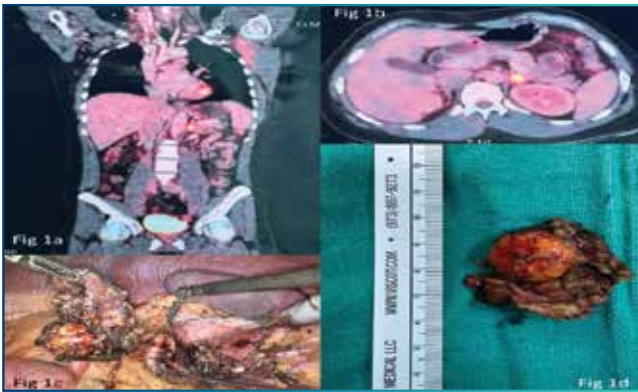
(a) sagittal section, (b) transverse section of 5-fluorodeoxyglucose positron emission tomography-computed tomography (5-FDG PET-CT) scan showing FDG-avid lesion in left adrenal gland, (c) intraoperative image, (d) image of the excised tumour.
